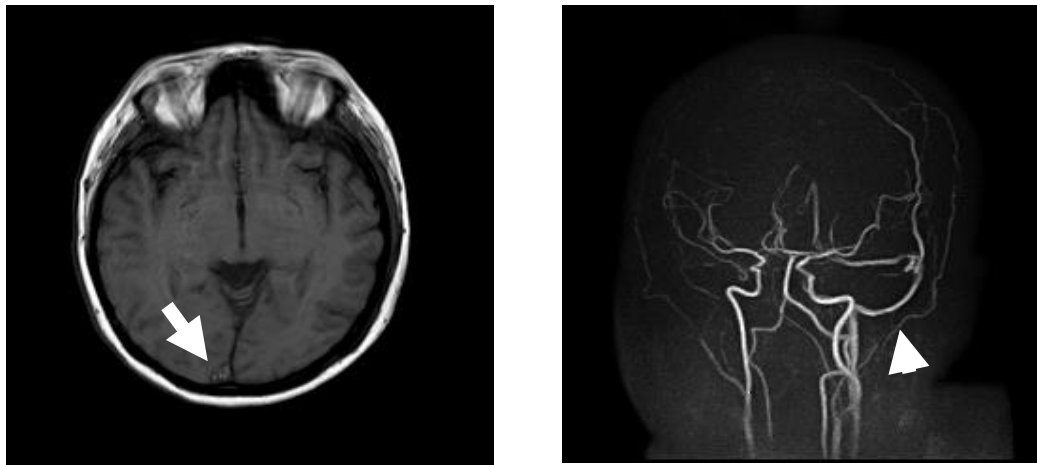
Non-Contrast Head MRI and MRA
